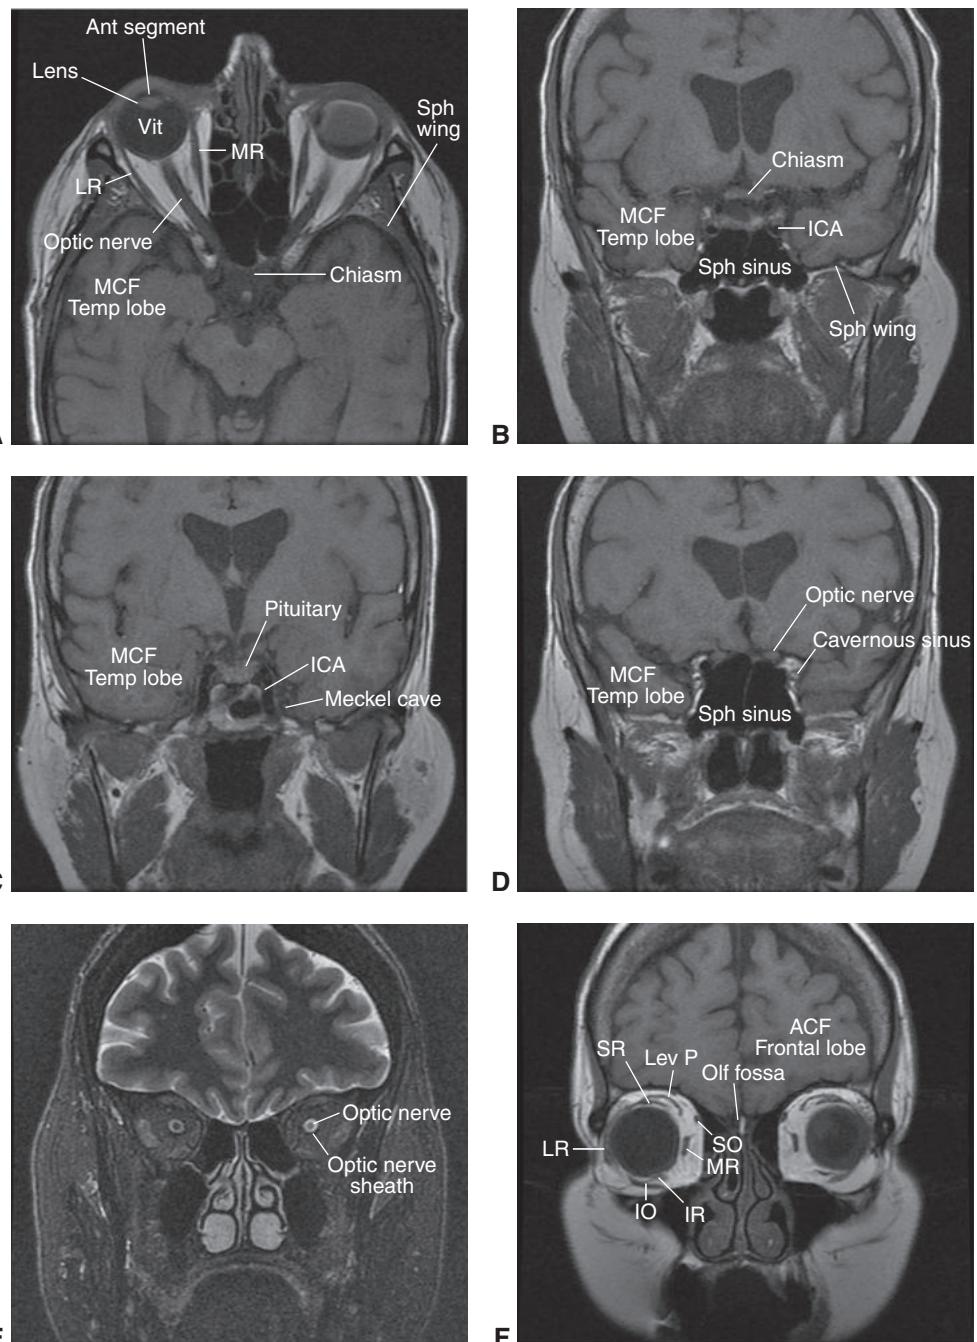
Brain and orbital magnetic resonance (MR) images showing the anatomy of visual and orbital structures from the chiasm to the anterior orbit. (The left-globe abnormality is not pertinent to the figure's objective.) A, T1-weighted axial image. B–D, T1-weighted coronal images. E, T2-weighted coronal image with fat saturation. F, T1-weighted coronal image. ACF = anterior cranial fossa; Ant segment = anterior segment; ICA = internal carotid artery; IO = inferior oblique muscle; IR = inferior rectus muscle; LR = lateral rectus muscle; Lev P = levator palpebrae superioris muscle; MCF = middle cranial fossa; MR = medial rectus muscle; Olf fossa = olfactory fossa; SO = superior oblique muscle; Sph sinus = sphenoid sinus; Sph wing = sphenoid wing; SR = superior rectus muscle; Temp lobe = temporal lobe; Vit = vitreous. (Courtesy of M. Tariq Bhatti, MD.)
